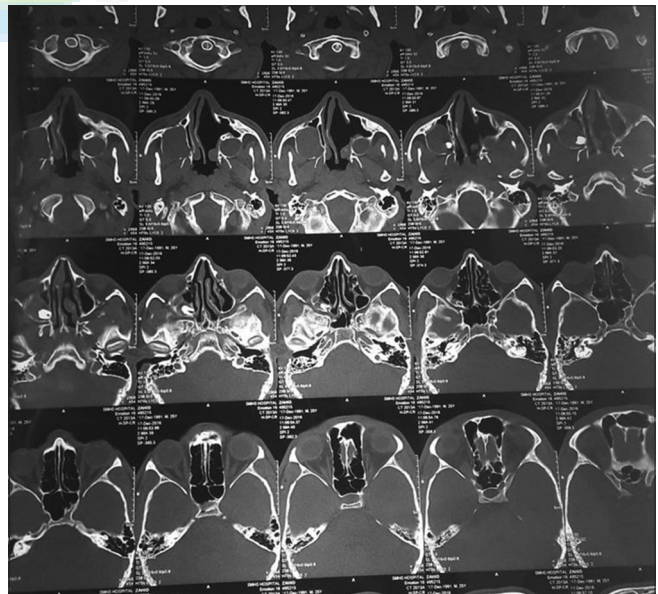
Computed tomography scan showing maxillary cysts
